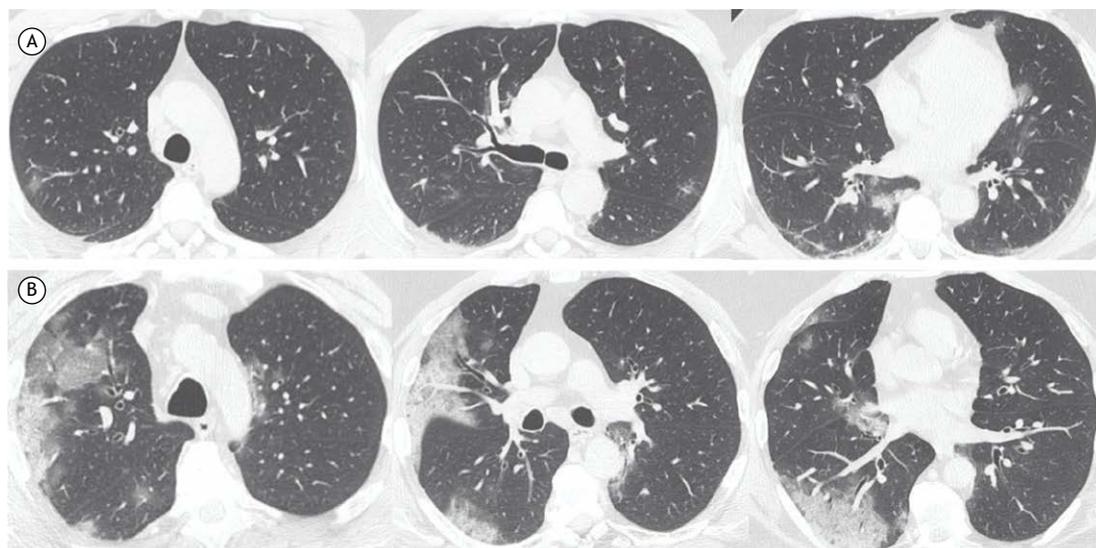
Chest CT scans of two patients with COVID-19, both of whom had an approximately 10-day history of respiratory symptoms. In A, a 48-year-old male patient with no comorbidities and an SpO₂ of 89% on room air, as well as a D-dimer level of 2,600 ng/mL. In B, a 62-year-old male patient with hypertension and diabetes, as well as an SpO₂ of 95% on room air and a D-dimer level of 420 ng/mL.
